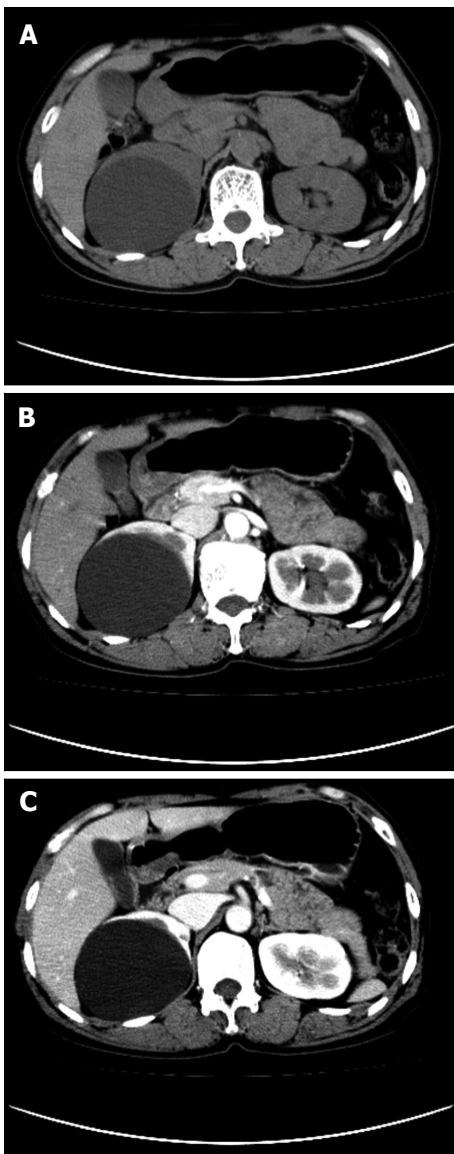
A 60-year-old female patient with mucosa-associated lymphoid tissue in gastric antrum. The tumor reveals as segmental, smooth homogeneous wall thickening on non-contrast computed tomography (A), minimal enhancement on arterial (B) and venous (C) phase enhancement.
